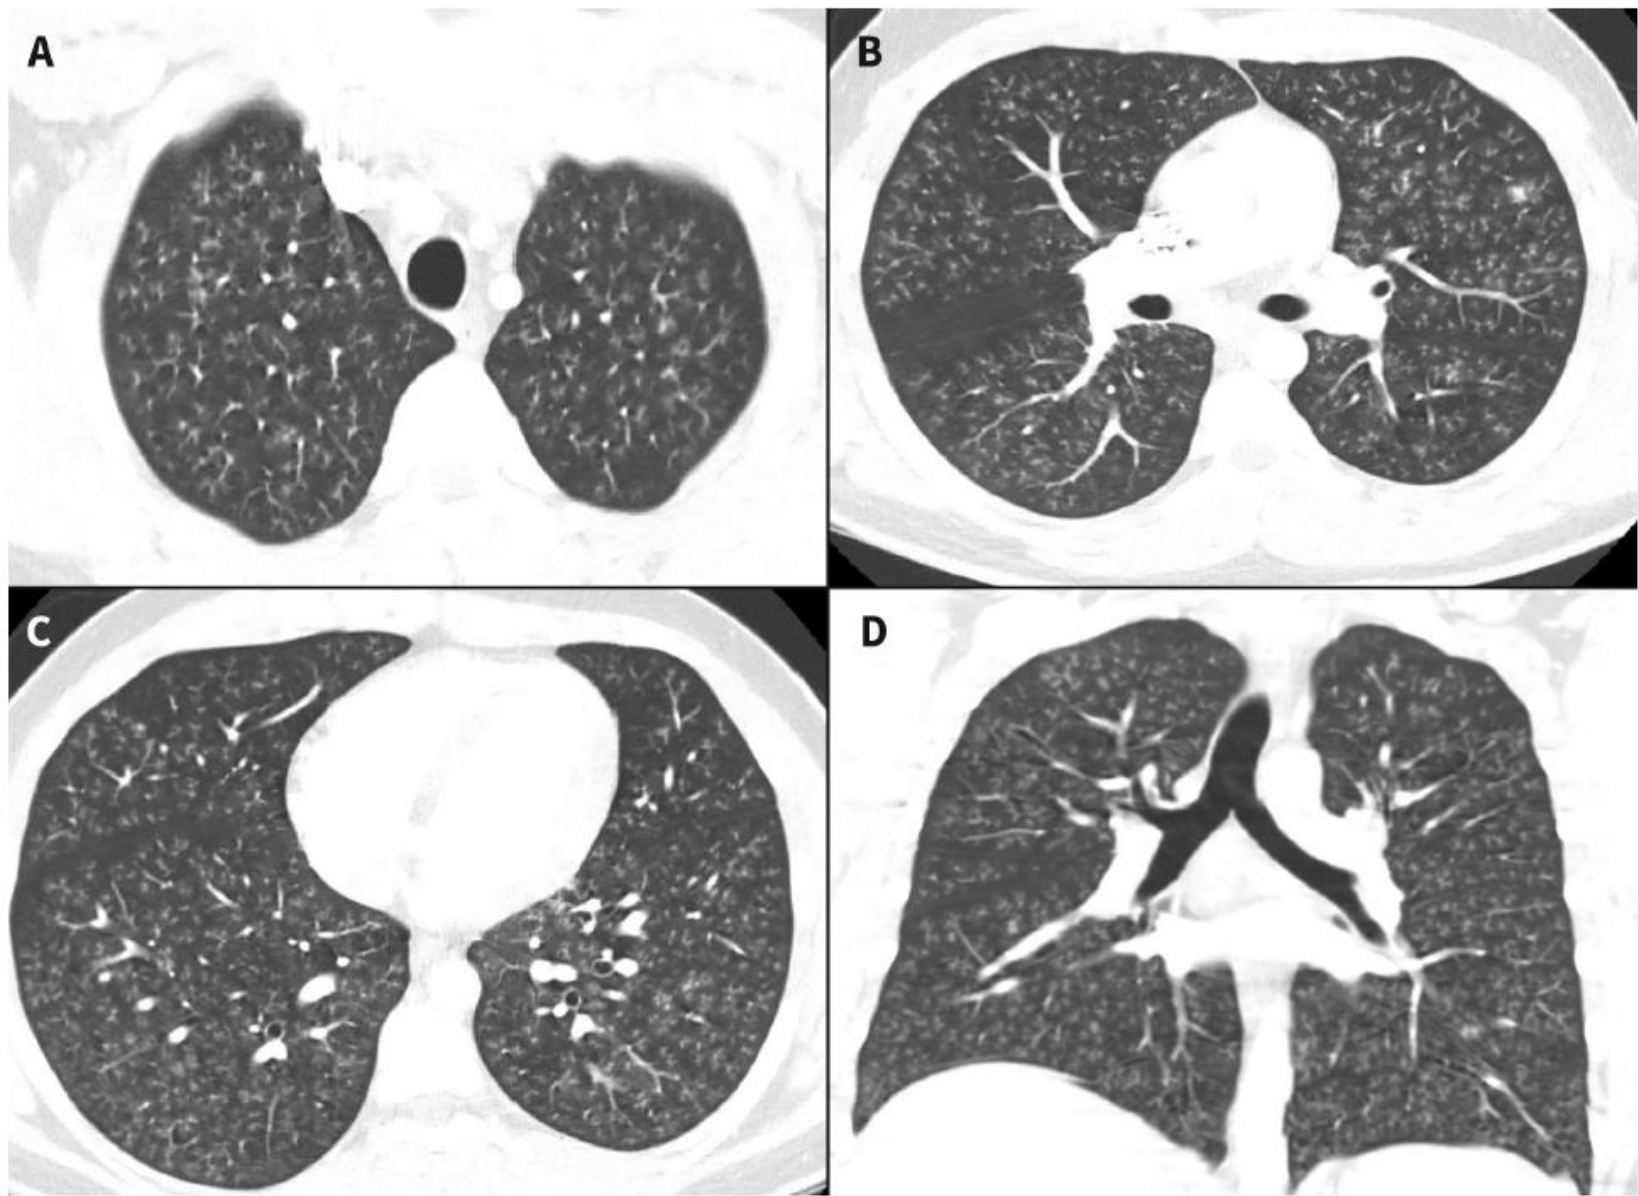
Computed tomography chest imaging on day 1 of hospital admission. Axial (panels A, B and C) and coronal (panel D) images show diffuse bronchiolitis manifested by innumerable tree-in-bud opacities throughout both lungs with subpleural sparing. Note the absence of mosaic attenuation, ground-glass opacity and consolidation.
